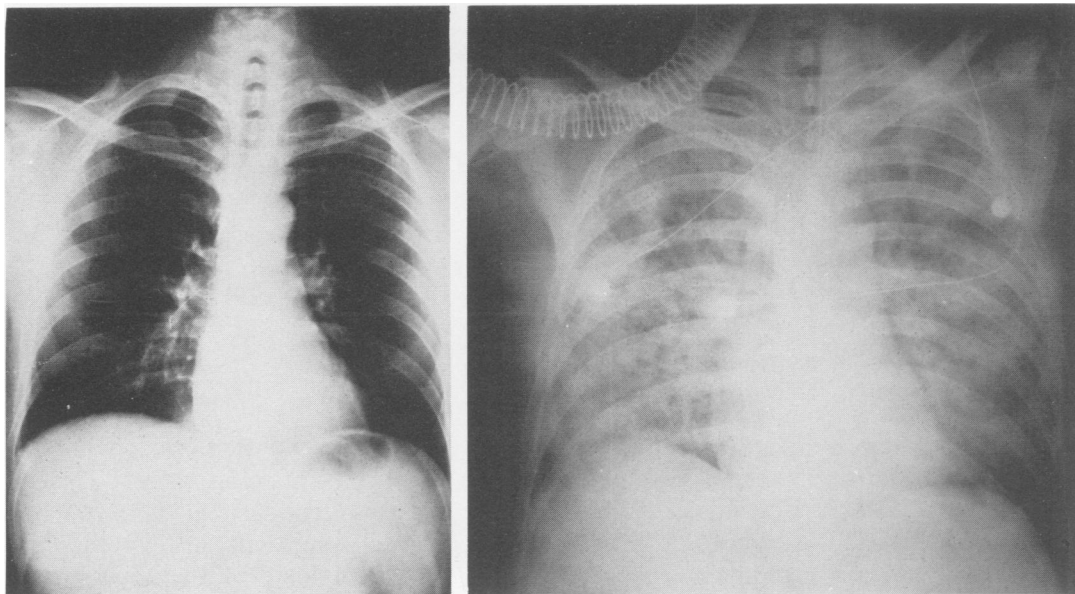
Radiographs of the chest (patient 3) on admission (left) and on the 3rd hospital day (right), after endotracheal intubation for acute pulmonary edema.
